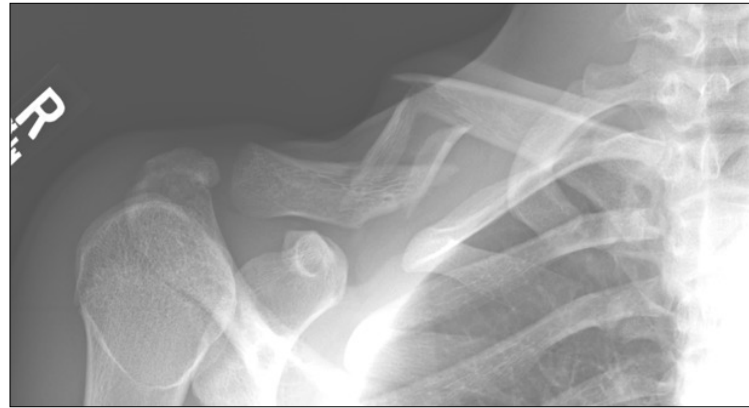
An injury radiographic of a mid-shaft 4-part, segmental, comminuted clavicle fracture with skin tenting in a 17-year-old male.
